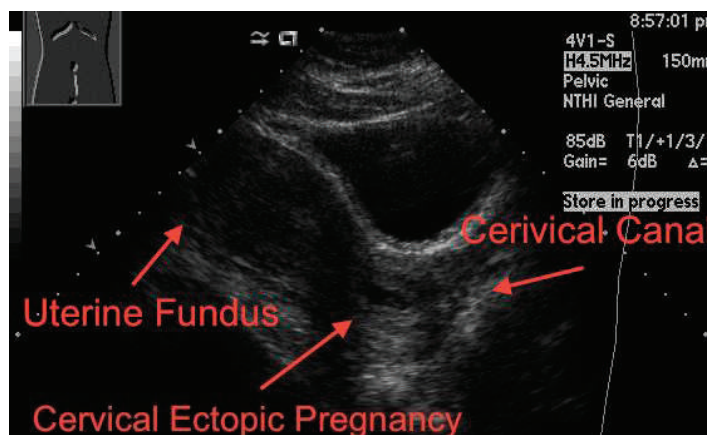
Transabdominal ultrasound in longitudinal plane.
